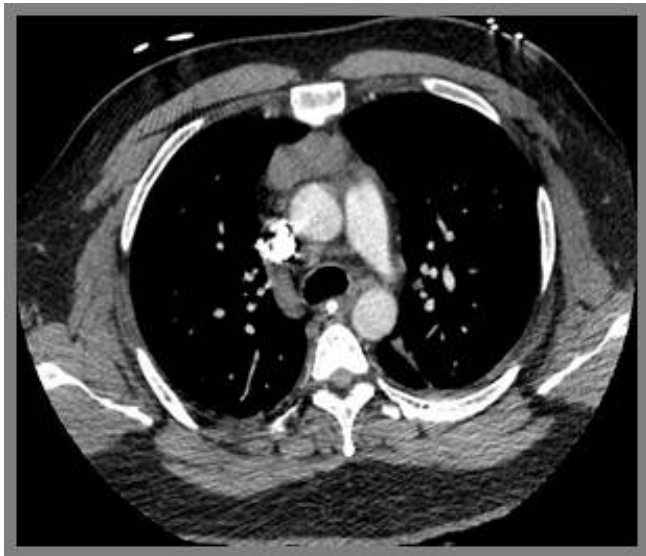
Anterior mediastinal mass on CT of chest with IV contrast
